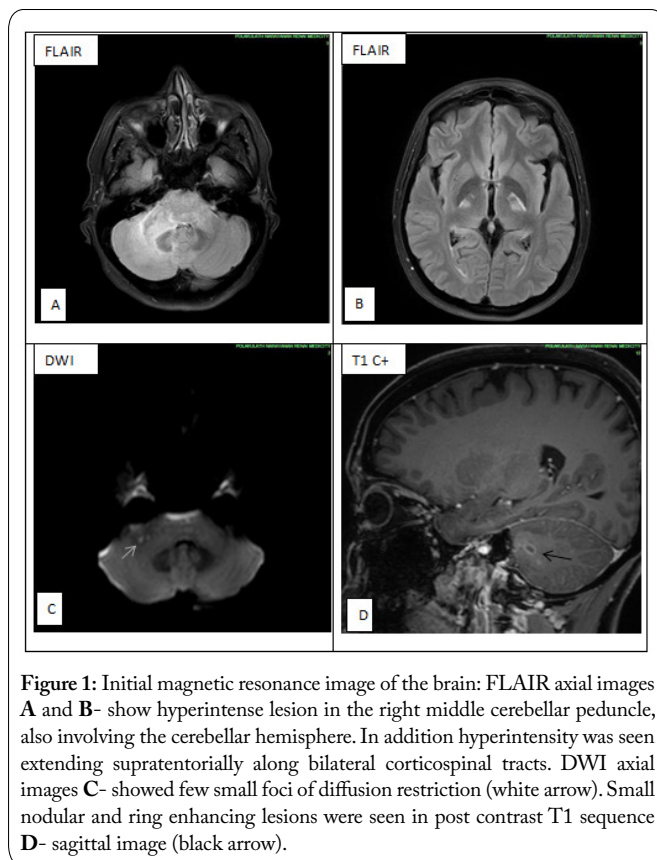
Initial magnetic resonance image of the brain: FLAIR axial images A and B- show hyperintense lesion in the right middle cerebellar peduncle, also involving the cerebellar hemisphere. In addition hyperintensity was seen extending supratentorially along bilateral corticospinal tracts. DWI axial images C- showed few small foci of diffusion restriction (white arrow). Small nodular and ring enhancing lesions were seen in post contrast T1 sequence D- sagittal image (black arrow).
